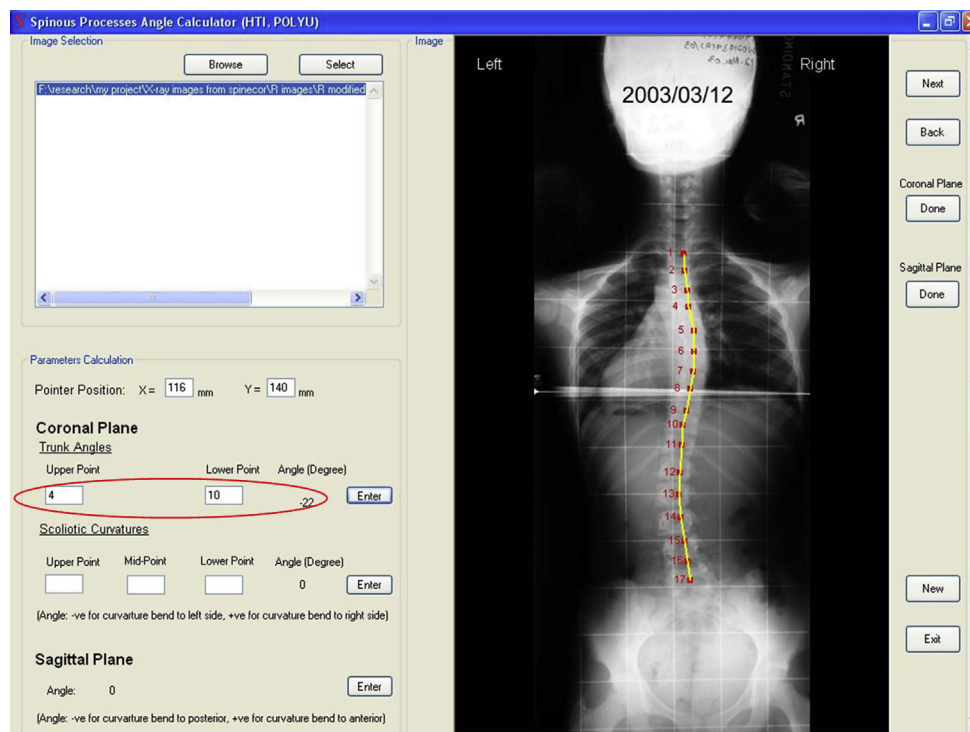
Spinous process angle calculator for measurements of SPA from radiograph.
